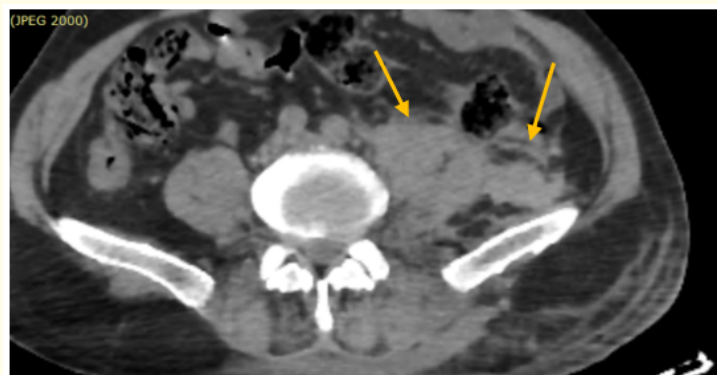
Axial section of an abdominal CT scan showing a hematoma of the left psoas muscle with a retroperitoneal hemorrhage.
